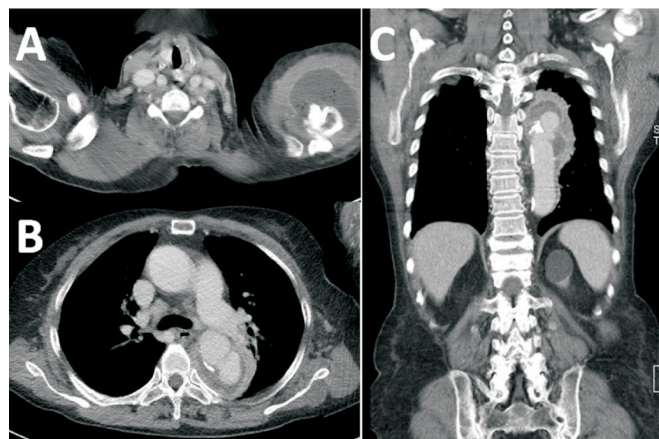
Axial view of computed tomography (CT) of aorta depicting a hypodense lesion with air-pockets within the deltoid muscle (A). Axial and coronal views of CT demonstrating an irregular-shaped wall of descending aorta with fluid accumulation and periaortic soft tissue mass (B and C).
